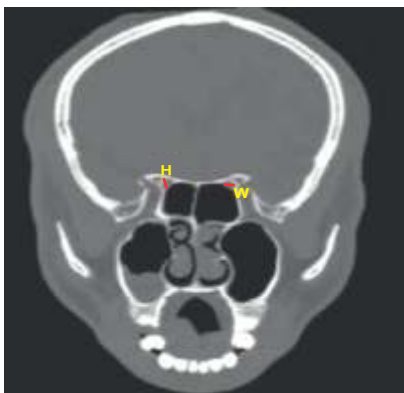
Coronal CT image showing the measurement of the height (H) and width (W) of the optic canal
